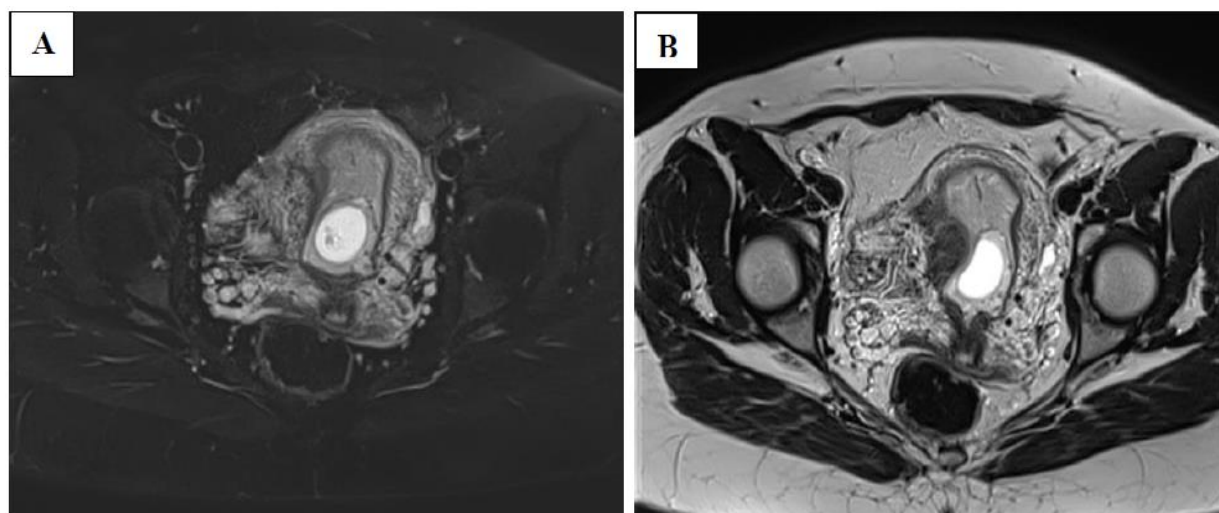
MRI images of the c-section scar ectopic pregnancy. (A) T2 axial FAT SAT. (B) and (C) T2 axial and sagittal views.
